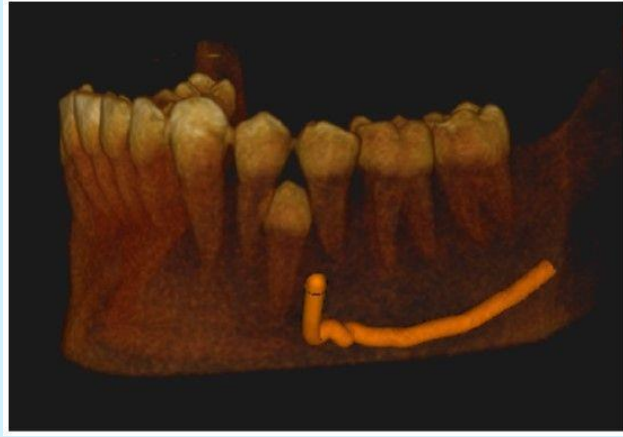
CBCT image-3D reconstruction, buccal view
